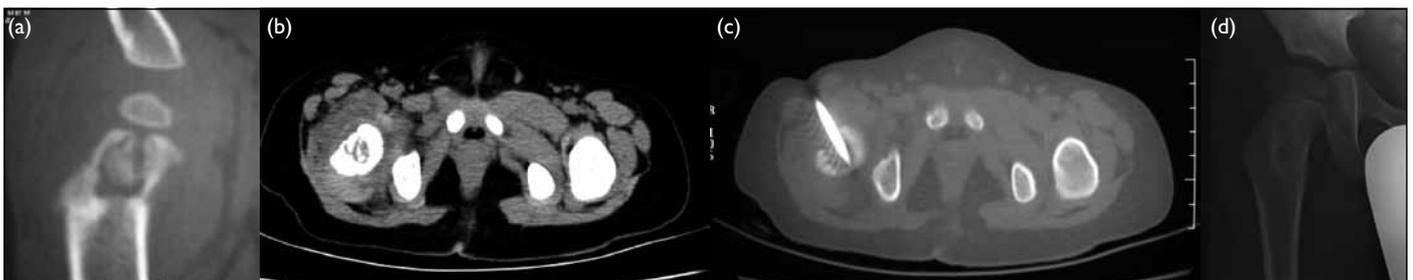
(a) Computed tomographic (CT) coronal reconstruction film showing an osteolytic lesion with a partially preserved bone matrix in the proximal femur metaphysis; (b) CT transverse cut of the right proximal femur showing the osteolytic lesion; (c) CT-guided biopsy of the osteolytic lesion; (d) X-ray of the right hip taken 3 years after the onset of the disease showing that the radiolucent lesion has almost resolved
